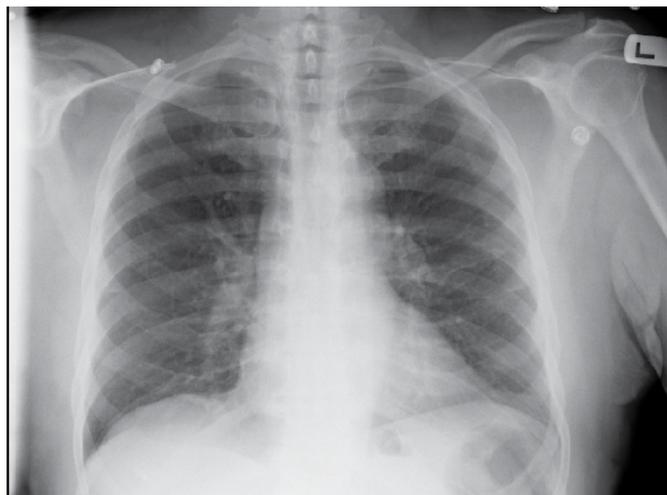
Chest X-ray (posterior-anterior view) after anti-TB treatment.
